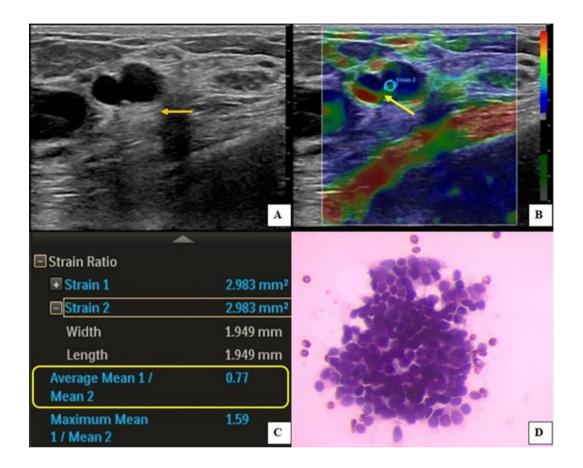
Ultrasonography in 40-year lady with left mastalgia showed (Fig A) well-defined, ovoid, anechoic cystic lesion with posterior acoustic enhancement (thick orange arrow), suggestive of BIRADS 2 lesion. On elastography (Fig B), the lesion demonstrated BGR trichromatic interface pattern (thick yellow arrow, score 0) in modified colour score. Mean strain ratio was 0.77 (Fig C; yellow box) suggestive of benign cystic lesion. FNAC showed benign ductal epithelial cells arranges in sheets and clusters (Fig D)
